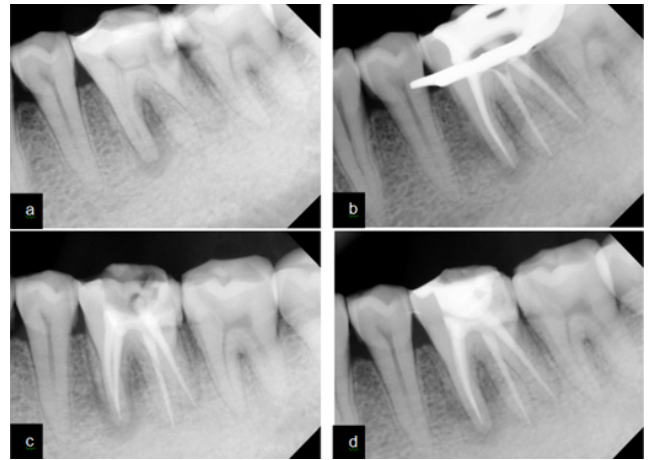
Pre operative radiograph of tooth number 36 shows additional disto lingual root, presence of peri apical radiolucency in mesial and distal roots; a: Postoperative radiograph(b).
